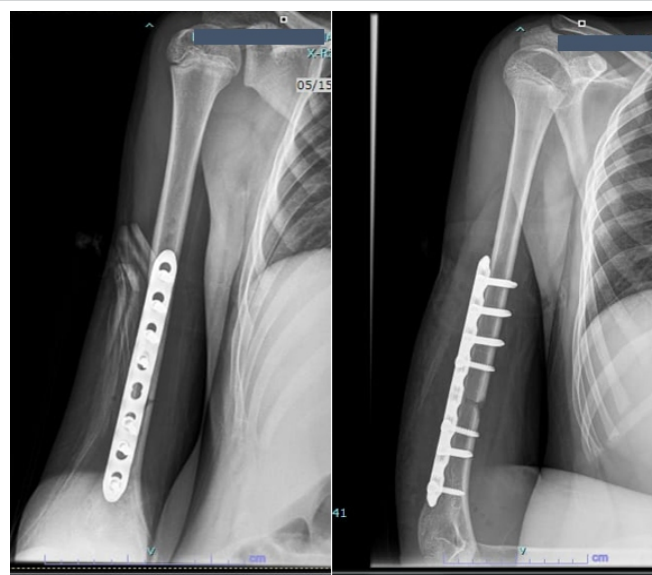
Post-operative radiograph after plating.
